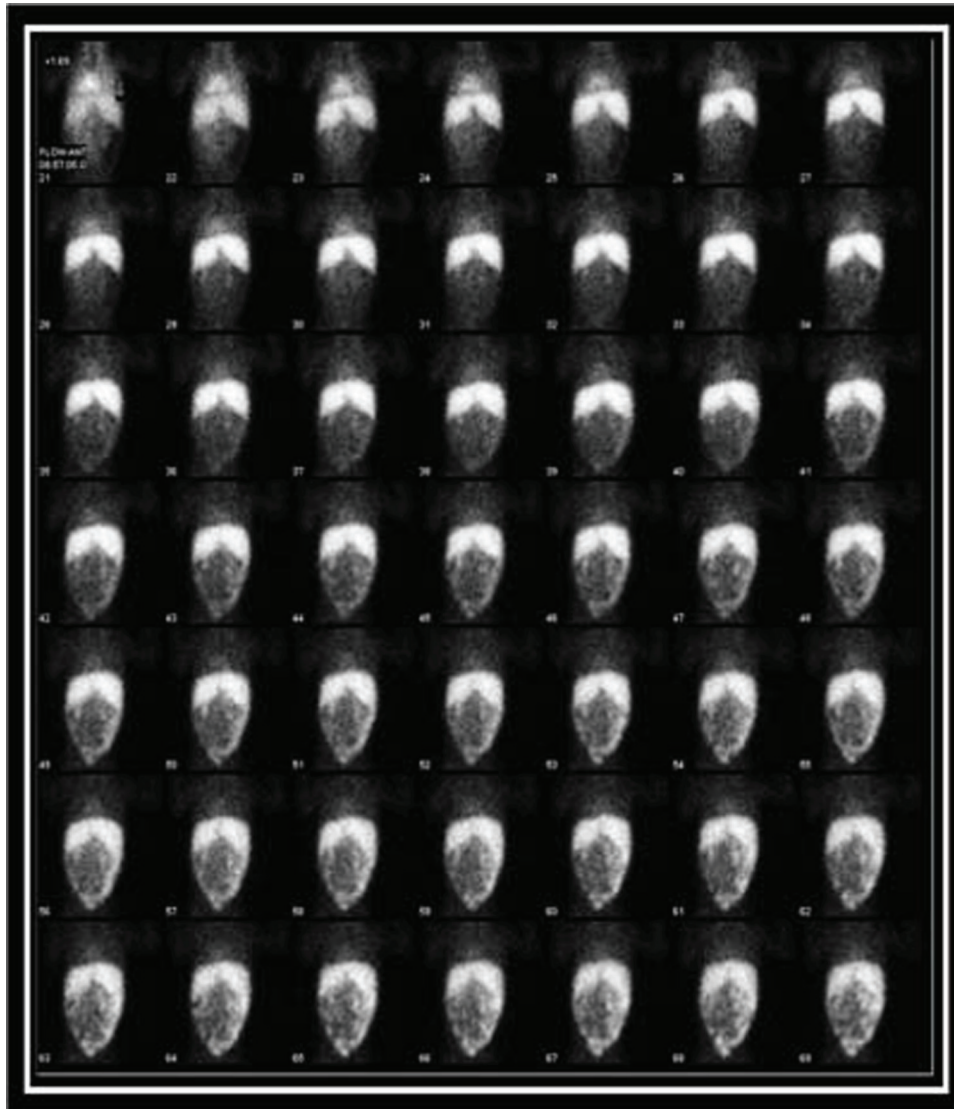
Anterior projection dynamic images of Tc-99m hidroksiiminodiaceticacid (HIDA) scintigraphy.
